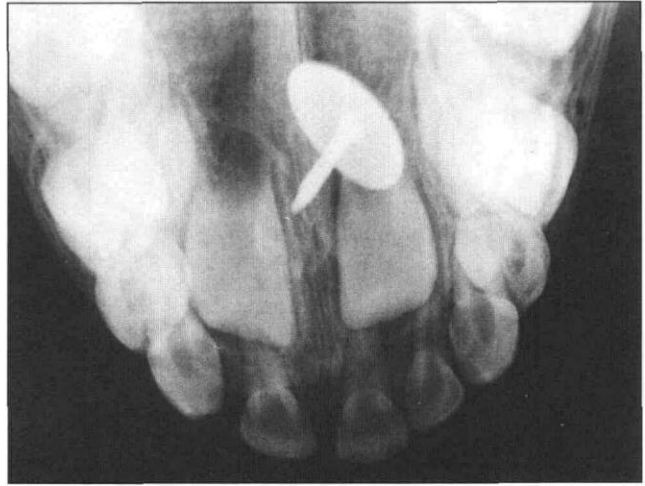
Maxillary occlusal radiograph of tack.
